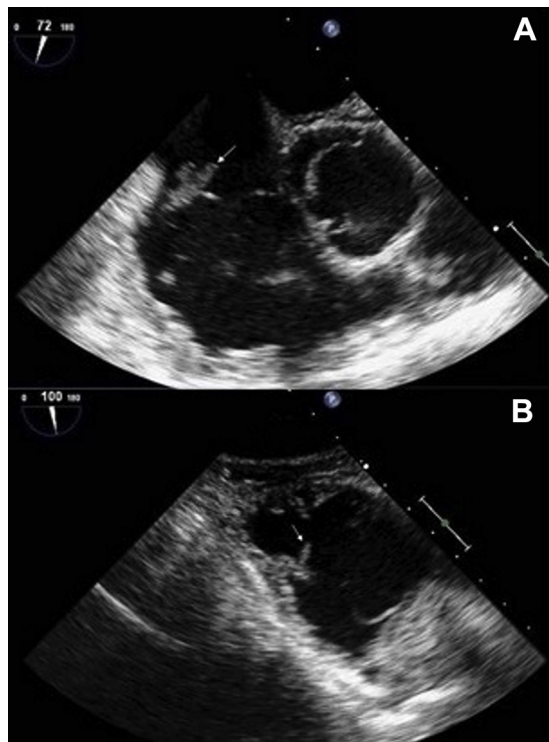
A, Mid-esophageal view at the level of the aortic valve with transesophageal echocardiography demonstrates a 7- to 8-mm mobile mass (arrow) attached to the atrial surface of the tricuspid valve. B, Transesophageal echocardiogram (transgastric right ventricular view) demonstrates a linear, independently mobile structure (arrow) attached to a papillary muscle in the right ventricle.
